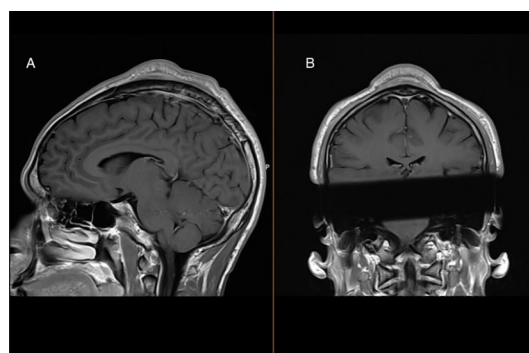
T1-weighted MRI with contrast of the tumour mass in sagittal (A) and coronal (B) planes.
